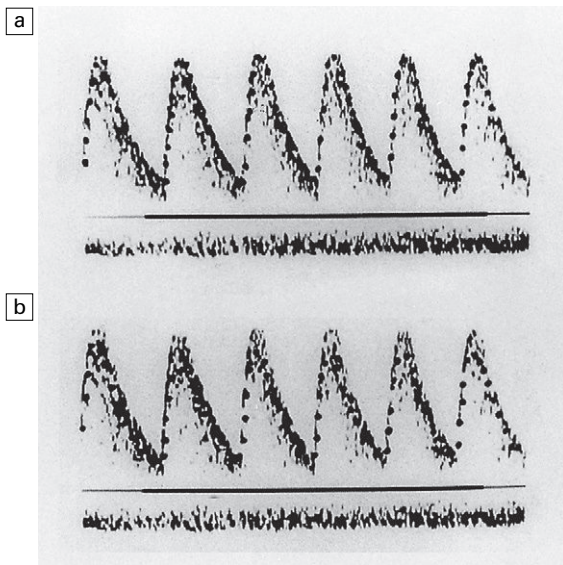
(a) A maximum-velocity trace on a sonogram. (b) A mean velocity on a sonogram.
